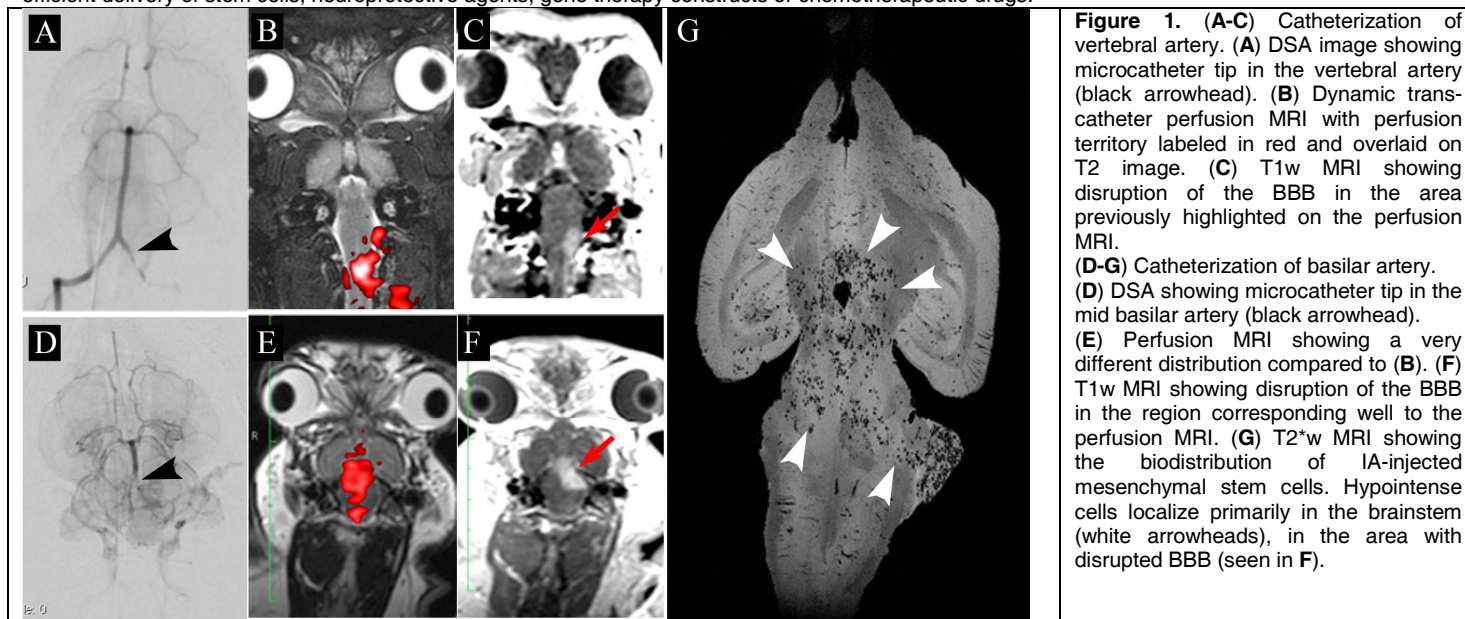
(A-C) Catheterization of vertebral artery. (A) DSA image showing microcatheter tip in the vertebral artery (black arrowhead). (B) Dynamic trans-catheter perfusion MRI with perfusion territory labeled in red and overlaid on T2 image. (C) T1w MRI showing disruption of the BBB in the area previously highlighted on the perfusion MRI. (D-G) Catheterization of basilar artery. (D) DSA showing microcatheter tip in the mid basilar artery (black arrowhead). (E) Perfusion MRI showing a very different distribution compared to (B). (F) T1w MRI showing disruption of the BBB in the region corresponding well to the perfusion MRI. (G) T2*w MRI showing the biodistribution of IA-injected mesenchymal stem cells. Hypointense cells localize primarily in the brainstem (white arrowheads), in the area with disrupted BBB (seen in F).
